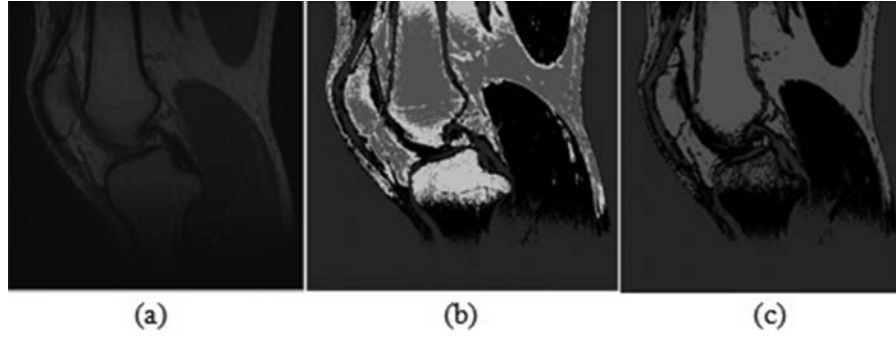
Performing k -means on the MRI of the knee bone. (a) Original image. (b) Performing k -means with $k = 4$. (c) Performing k -means with $k = 3$.
